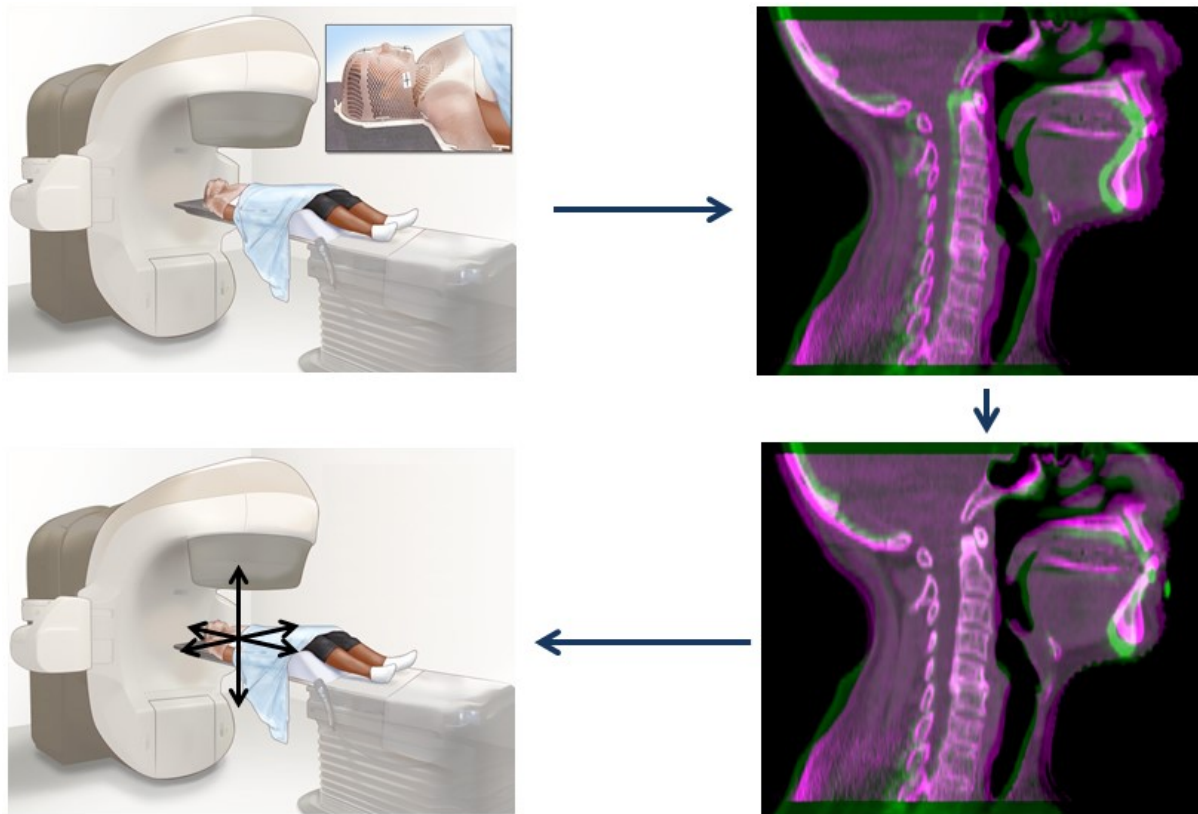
Reduction of setup errors in image guided radiotherapy (IGRT): (top left) The patient is positioned on the treatment couch with a head support and thermoplastic fixation mask in an attempt to reproduce the planning computed tomography (pCT) scan position; (top right) A cone beam CT (CBCT) scan is taken (magenta) and digitally overlaid on the pCT (green); (bottom right) The CBCT and pCT are digitally matched by treatment staff prioritising a region of interest. In this case, the C1-C3 vertebral bodies; (bottom left) the digital match is applied to the treatment couch in three translational degrees of freedom. Note that an additional three rotational degrees of freedom can be used. Residual setup errors (bottom right) seen at the mandible and hyoid are non-rigid deformations. Top and bottom left panes revised and reproduced with permission: for the National Cancer Institute © (2016) Terese Winslow LLC, U.S. Govt. has certain rights.
